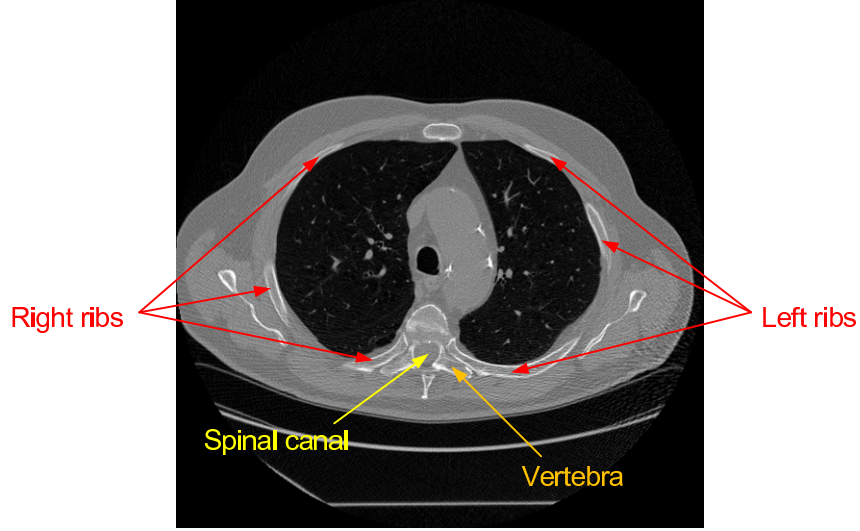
Spinal canal and ribs in a CT scan. An axial image slice is shown where the ribs, vertebra, and spinal canal are labeled.
